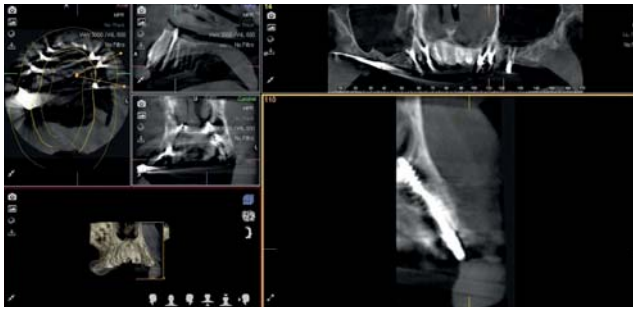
CT scan showing the anchoring of the BCS® implant in the second cortical, in the floor of the nose.
